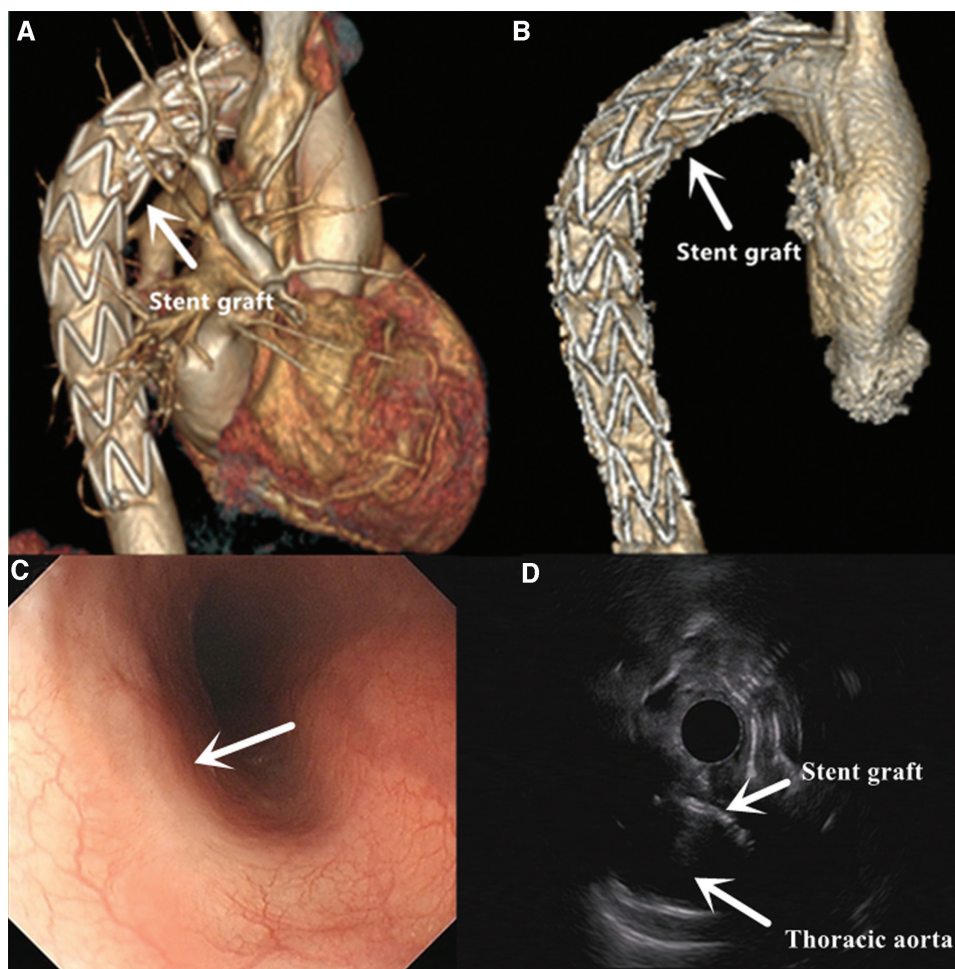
Examination 2 years later. (A, B) Three-dimensional volume-rendered computed tomography angiography shows a well-positioned thoracic aortic stent. No contrast extravasations into the aneurysmal sac. (C) Esophagogastroduodenoscopy shows a completely healed esophageal submucosal tumor-like protrusion with an ulcerative lesion. (D) Ultrasound gastroscopy shows a strong half-moon echo between the aortic wall and the esophageal wall.
